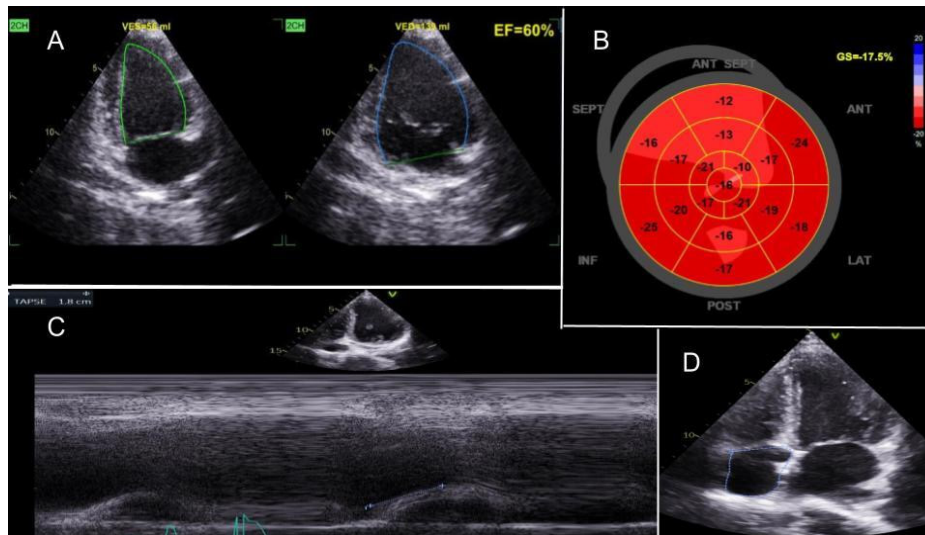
Post-treatment evaluation of transthoracic echocardiography revealed: (A) Improved LV ejection fraction (LVEF) to 57%; (B) Improved LV GLS value to [-17.5 %]; (C) Improved RV systolic function to TAPSE 18 mm; (D) Reduction in RA area. LV: left ventricular; LVEF: left ventricular ejection fraction; GLS: global longitudinal strain; RV: right ventricular; TAPSE: tricuspid annular plane systolic excursion; TR: tricuspid regurgitation. RA: right atrial.
